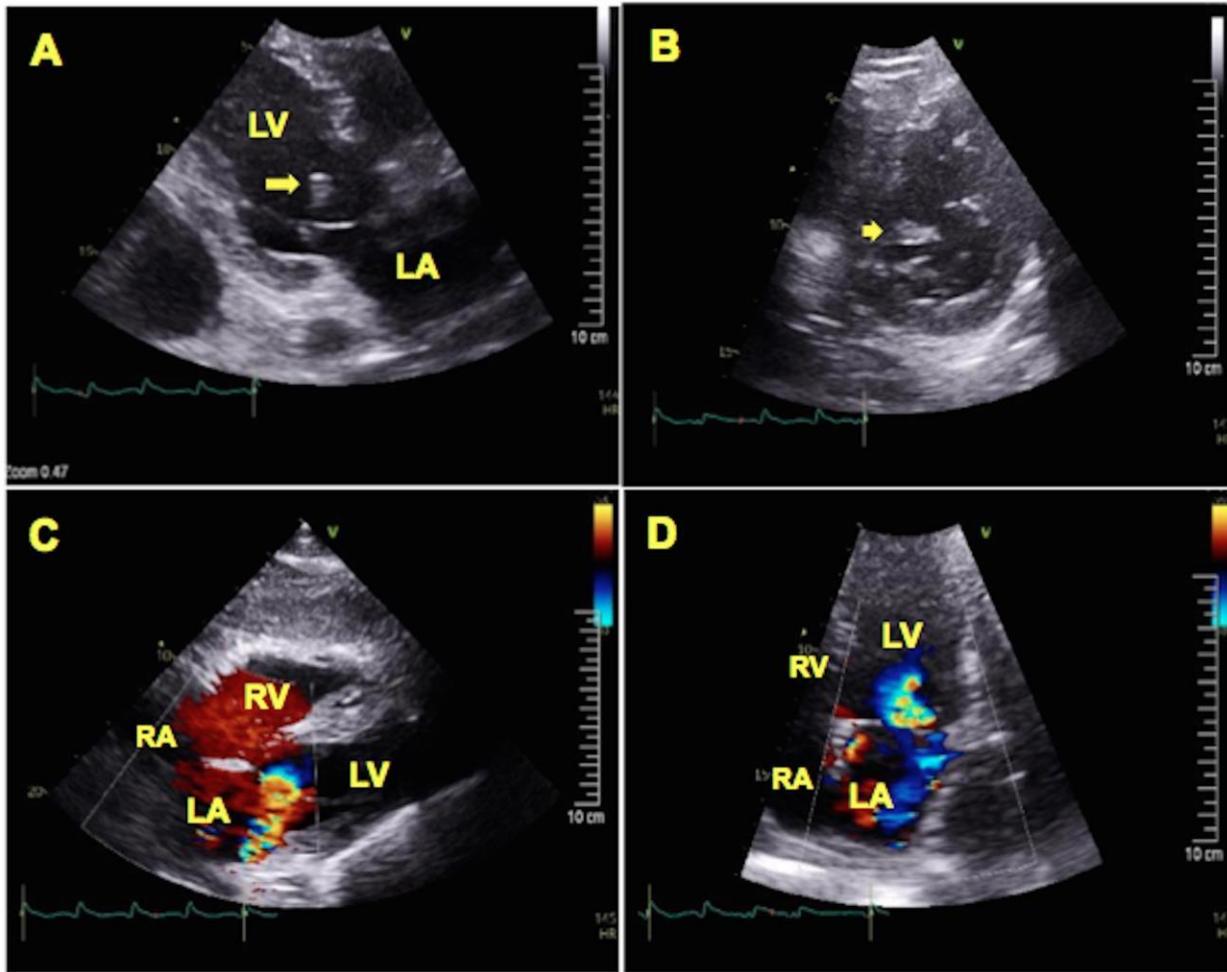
Transthoracic echocardiography. A- D
